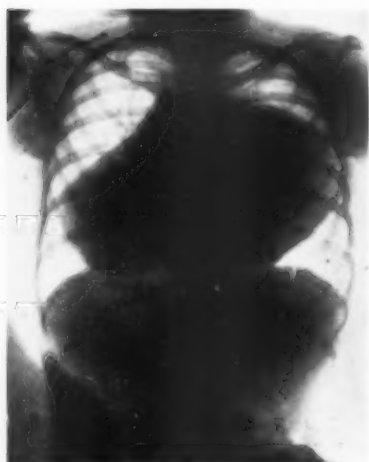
Dermoid cyst occupying greater part of the right side of the chest. This tumor is somewhat spherical and there is no expansile pulsation roentgenoscopically. The possibility of echinococcus cyst was considered because of its site. Cyst markedly adherent to the mediastinum and sternum so that it could not be completely removed.
